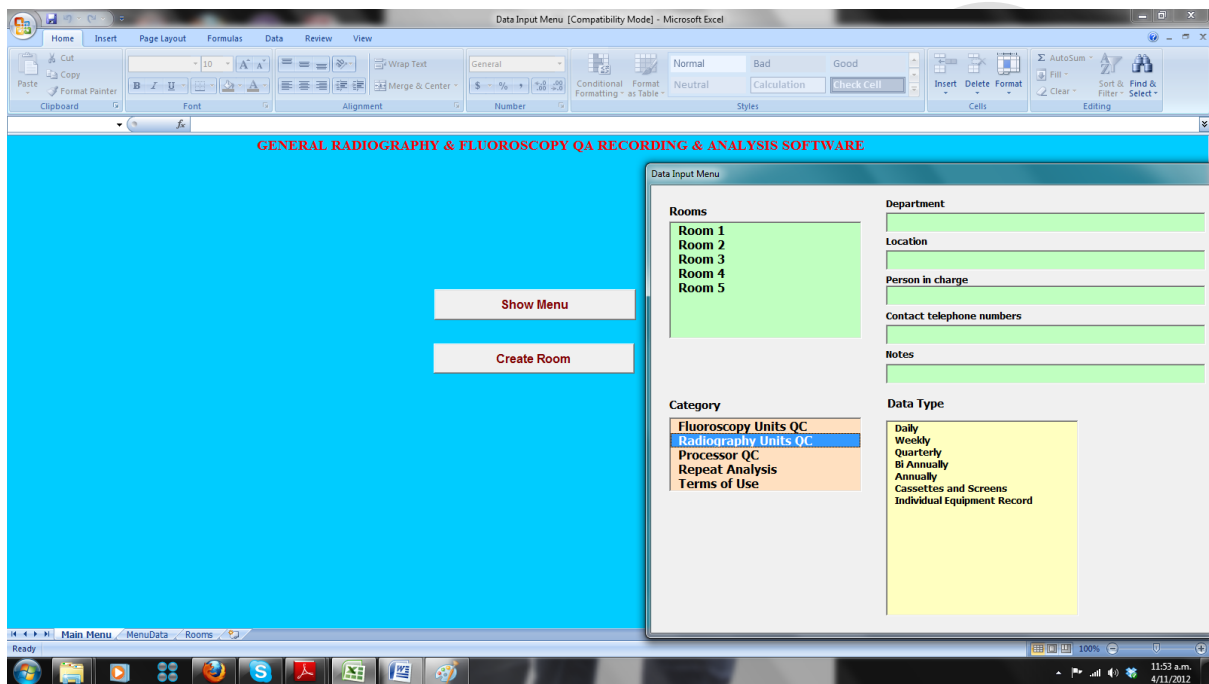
A screen capture showing the frequency of test options for the radiography modality.
